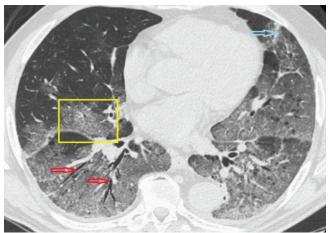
Axial HRCT scan of COVID-19 patient shows minimal left pleural effusion
